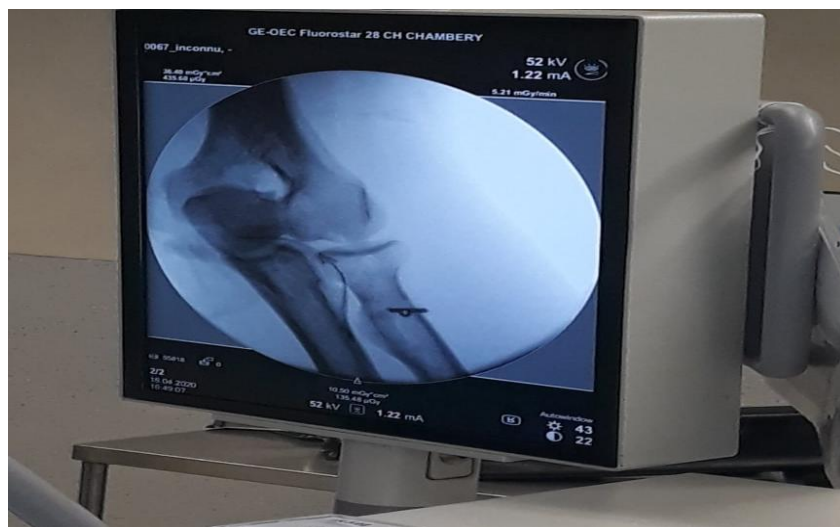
Peroperative X-ray confirms good position of the button
